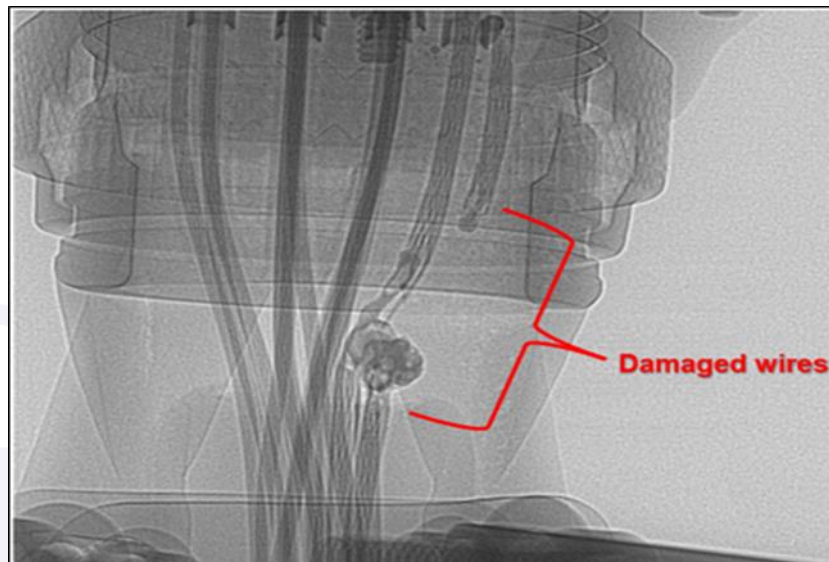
Overview of damage to the wiring on an x-ray inspection.
